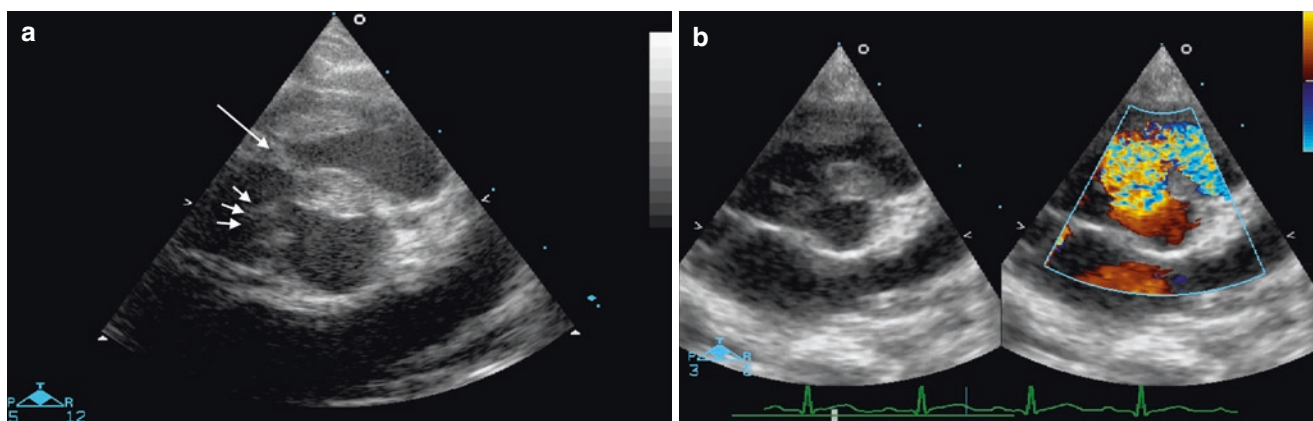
Parasternal short axis of the base of the heart showing a perimembranous VSD (a), which is partially occluded by accessory tricuspid valve tissue (arrows). In addition there is obstruction of the right
